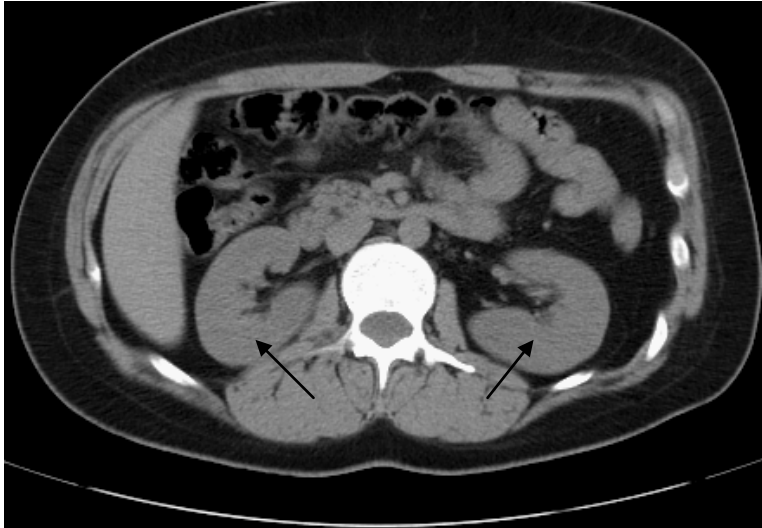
Normal CT kidneys. Note the homogeneous renal density on the noncontrast images (arrows)
